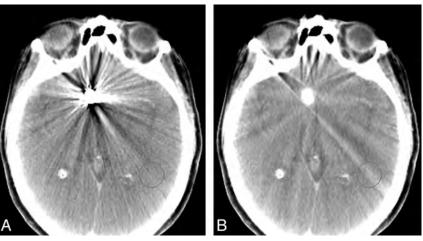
Conebeam CT data without (A) and with (B) MAR demonstrating the reduction of coil mass artifacts and the appearance of subtle streak caused by the algorithm, which is specifically well visualized in the indicated circular region of interest.
